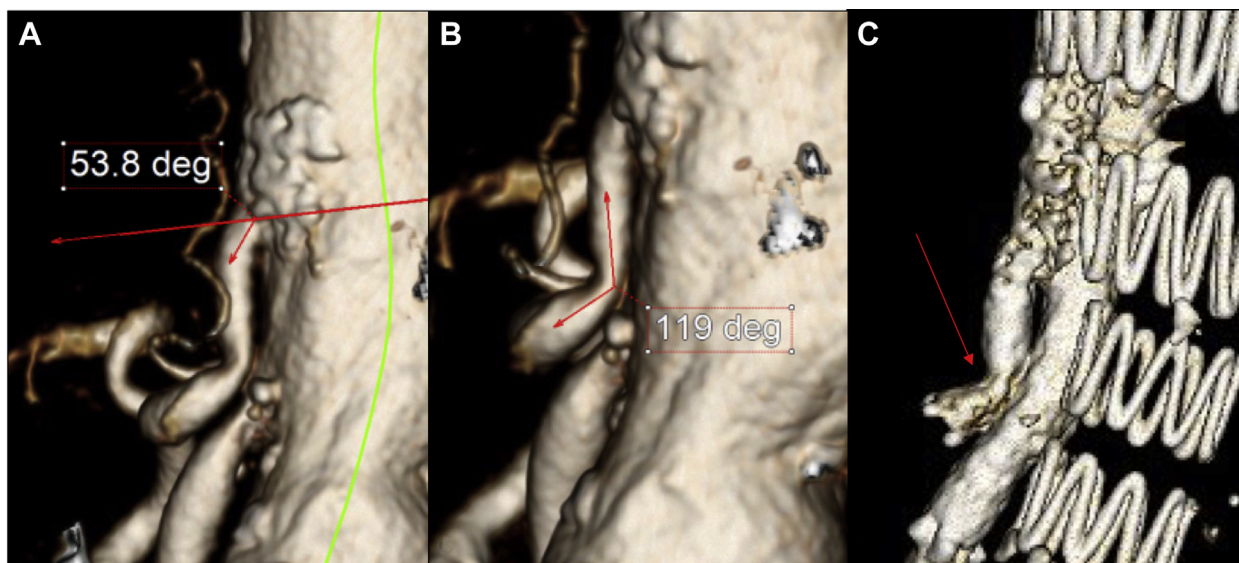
A, Three-dimensional preoperative computed tomography angiography (CTA) reconstruction showing the measurement of the shift angle (SA) in a patient with a pararenal aortic aneurysm. B, Measurement of the angle of emergence (AE) of the celiac artery (CA). C, Postoperative CTA of the same patient, showing kink of the stent at the level of the median arcuate ligament (MAL) (red arrow).
